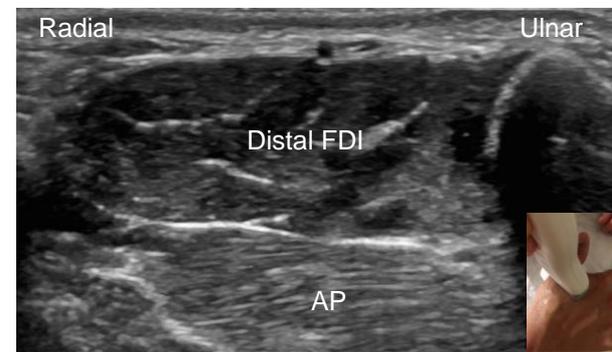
Ultrasound imaging of distal FDI with probe in the short axis of the muscle. Adductor pollicis (AP) is deep to the FDI.
